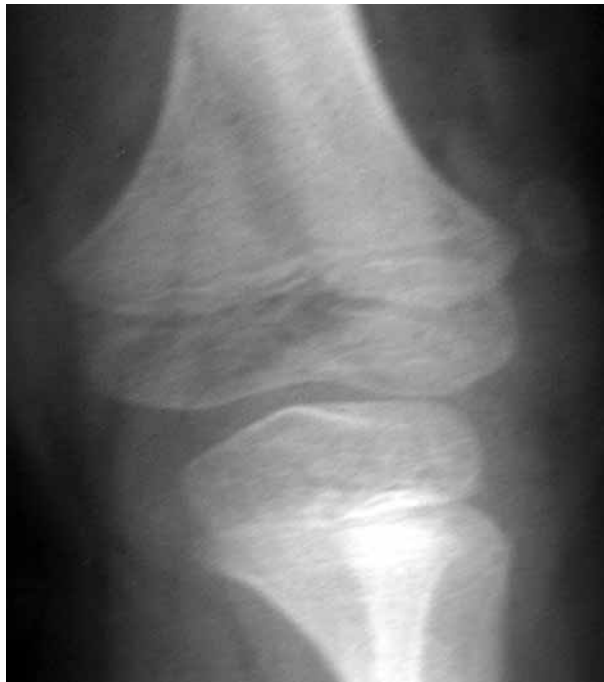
Radiograph of left knee of patient with Mulibrey Nanism syndrome with a dislocated left patella. Marked soft tissue contractures resulted in the external tibial torsion deformity seen in this true AP radiograph.
